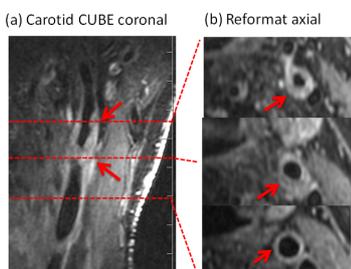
CUBE MRI of a patient with a significant plaque. (a) CUBE images in acquired coronal plane; (b) Reformatted CUBE images in the axial plane.
